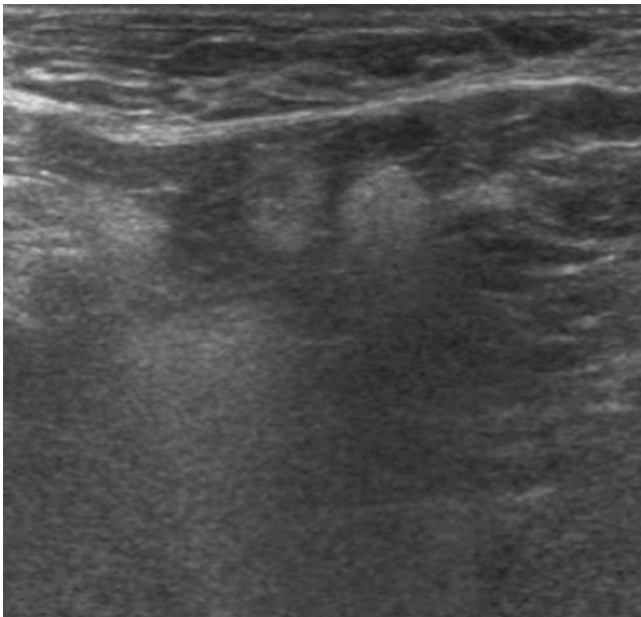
Ultrasound showing hyperechoic lymph nodes with the snowstorm sign indicating extracapsular rupture and silicone migration to axilla. This image appeared in the European Aesthetic Plastic Surgery Journal (number 12). Reproduced with permission from the Asociación Española de Cirugía Estética Plástica.
